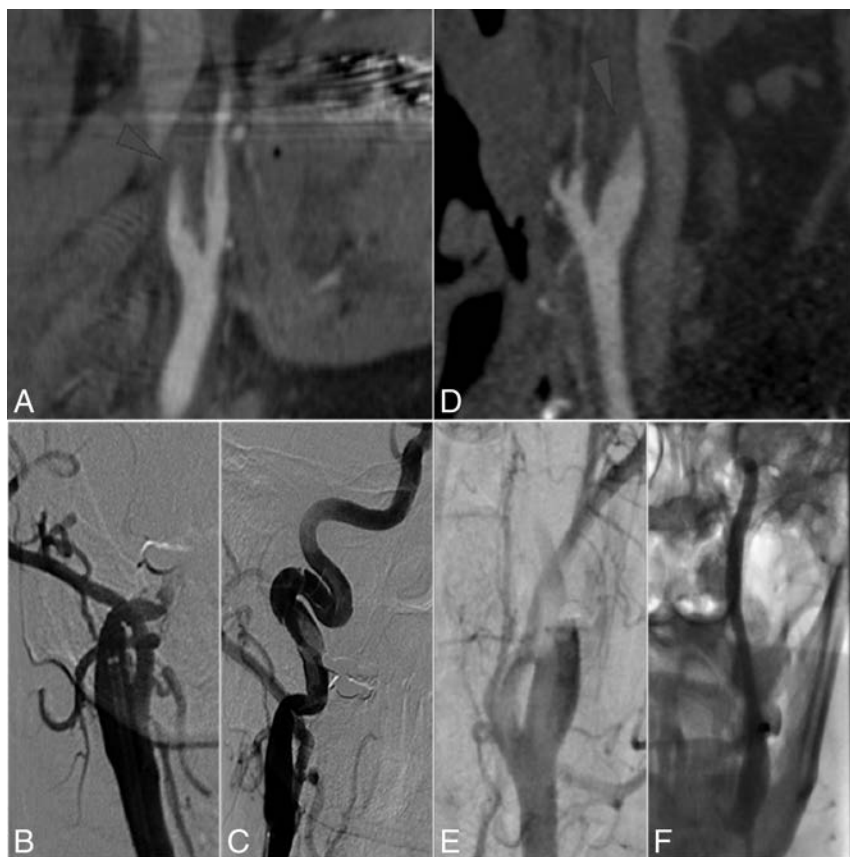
Examples of suspected dissection or pseudo-occlusion on CTA with a noncorresponding cause of apparent occlusion found on DSA. *A*, Dissection of the right ICA in a 65-year-old woman. CTA shows a blurred contrast cutoff above the level of the carotid bulb, suggesting pseudo-occlusion, without T-occlusion present. *B*, DSA of the patient in *A* shows major vessel wall irregularities and the impossibility of passing the occlusion with a catheter (*C*), indicating the presence of a dissection rather than pseudo-occlusion. *D*, Pseudo-occlusion of the left ICA in a 63-year-old man. CTA shows a sharp, diagonal contrast cutoff above the level of the carotid bifurcation, suggesting dissection, with T-occlusion present. *E*, DSA of patient in *D* shows a blurred contrast cutoff slowly moving upward and finally a patent ICA with intracranial carotid T-occlusion present (*F*), indicating pseudo-occlusion.
